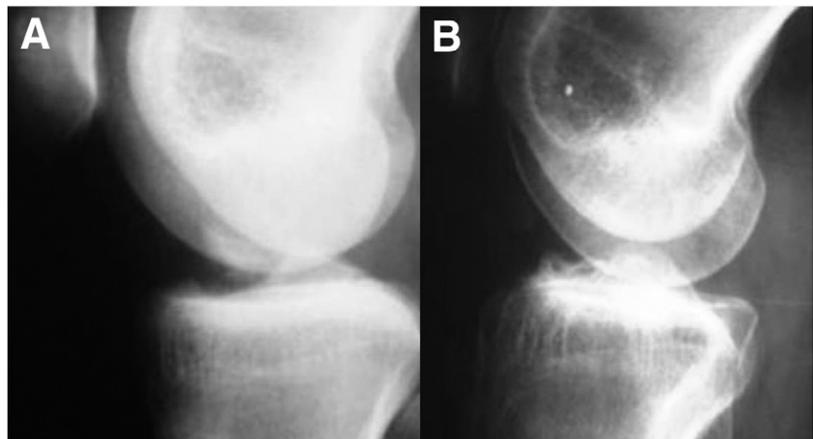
Anteroposterior and lateral radiographs showing healing of tibial eminence fracture shown in Fig 1.
